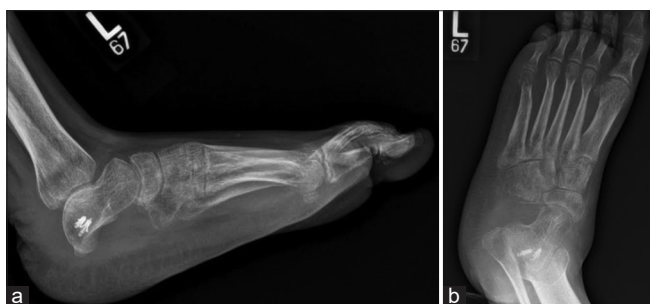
Radiographs of the foot at 6 months follow-up (a) lateral view and (b) anterior posterior oblique view.
